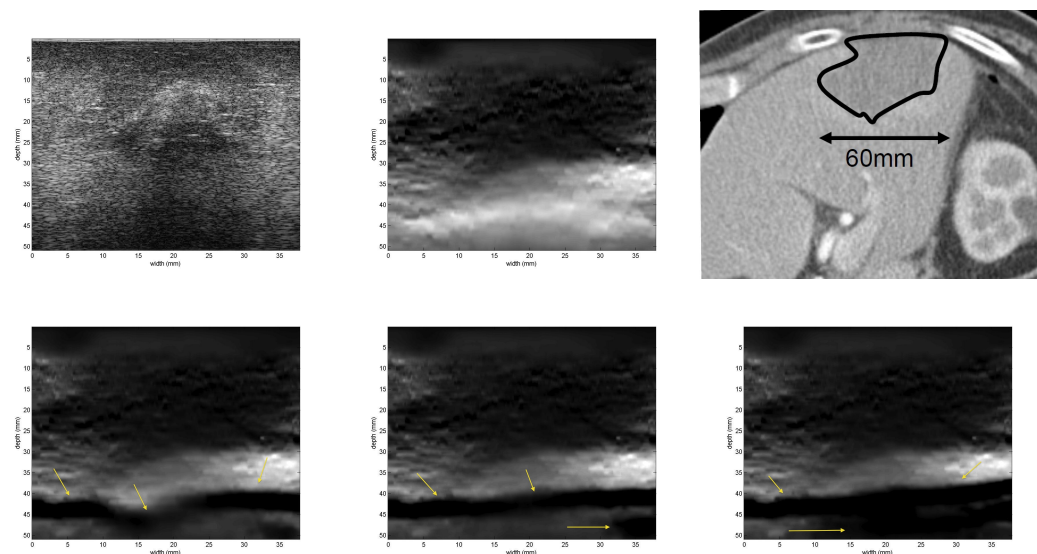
RF ablation therapy of liver cancer patient 3. All imaging was acquired after the ablation. B-mode (a), Elastography with the robust method (b) - The thermal lesion shows in as dark, surrounded by normal tissue in white., CT with delineated thermal lesions (c) and Elastography without the robust method (d-f).
